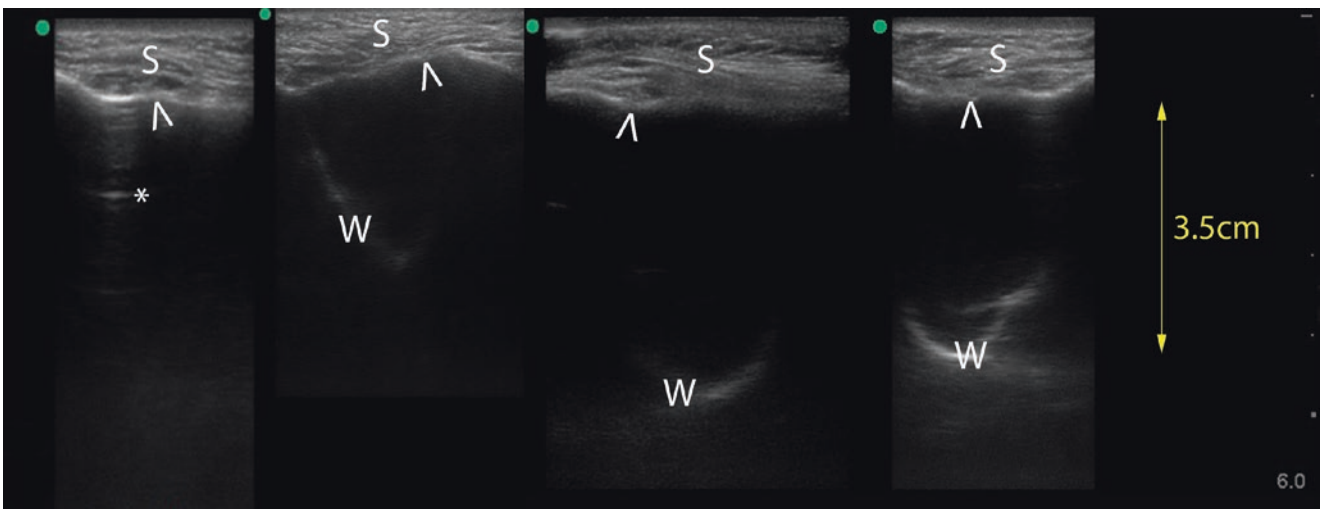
Spectrum of transverse maxillary sinus ultrasound findings: Here is the spectrum of transverse maxillary sinus ultrasound findings with *normal*, air-filled sinus on the left and *strongly positive* fluid-filled sinus on the right. The middle two images are *weakly positive* results seen with smaller amounts of fluid. In these middle two
